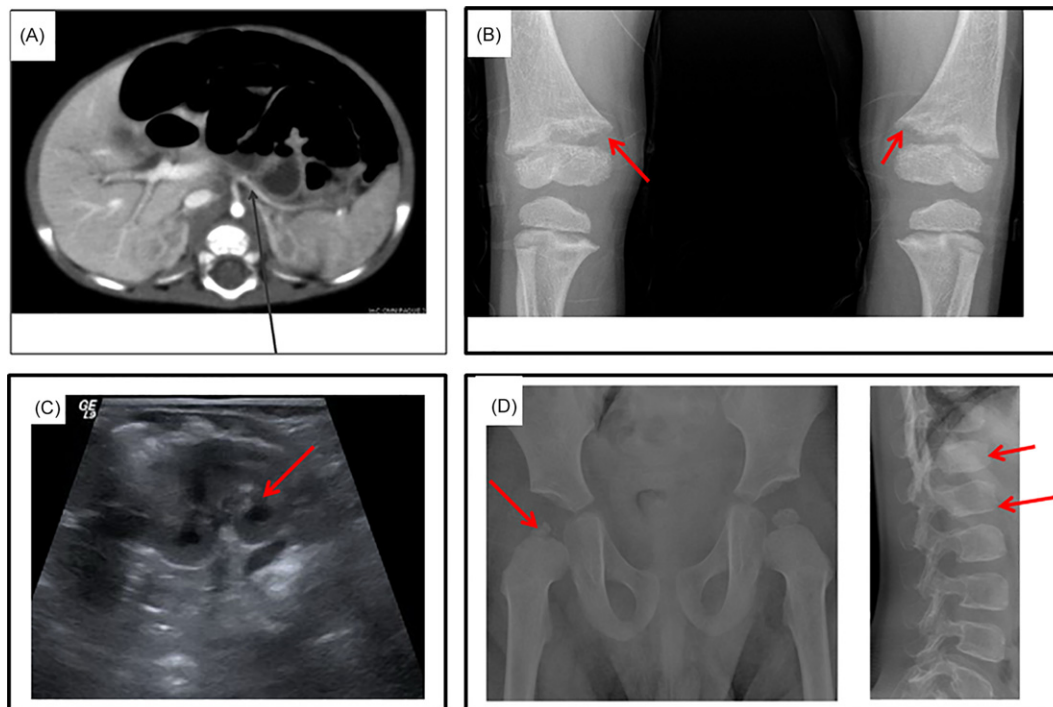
Radiological features detected in some children with neonatal diabetes: (A) computerized tomography of the abdomen showing pancreatic aplasia; (B) active rickets in both knees in a patient with Fanconi–Bickel syndrome; (C) renal ultrasound scan showing renal cysts in GLIS3 and WRS; (D) skeletal dysplasia in WRS (fragmented femoral head and thoraco-lumbar vertebra).
